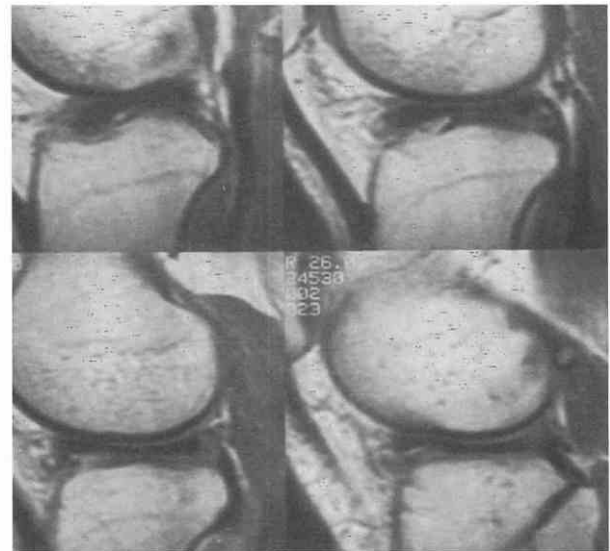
Discoid meniscus, sagittal views. Sagittal T2-weighted images show the lateral meniscus extending too far centrally, consistent with a discoid meniscus.
